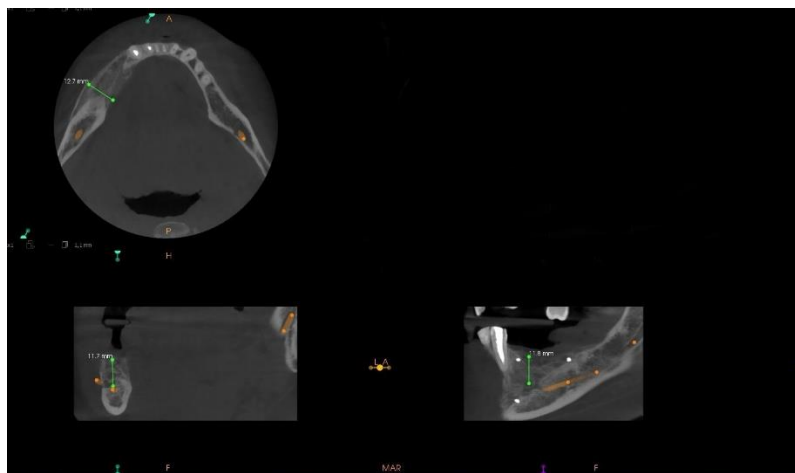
CBCT after 6 months.
